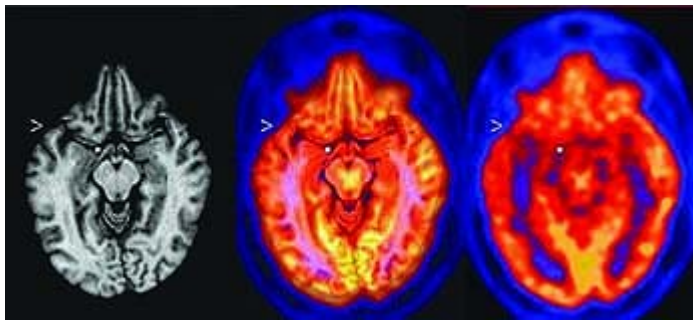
Coregistered axial image plane of magnetic resonance imaging (MRI) and interictal 2-deoxy-2- $[^{18}\text{F}]$ fluoro-D-glucose ($[^{18}\text{F}]$ FDG) positron emission tomography (PET) images of a limbic temporal lobe epilepsy (TLE) patient. The gray-scale MR image (left) and the color PET image (right) are coregistered in the center image. The MRI and PET data were reoriented parallel to a line through the anterior and posterior commissures. A widespread area of reduced $[^{18}\text{F}]$ FDG activity is evident on the left side of the PET image; inspection of the PET image alone does not clarify whether the reduction extends from mesial structures (at the dot internal to the brain FDG image) of the temporal lobe into the basal frontal lobe, nor whether the lateral temporal hypometabolism (at the arrowhead) extends above the sylvian fissure. The dot and arrowhead appear at the same coordinates in the MRI and the coregistered MRI-PET images as in the PET image, clarifying that all sites with severe hypometabolism are confined to the temporal lobe. (See black and white image.)
